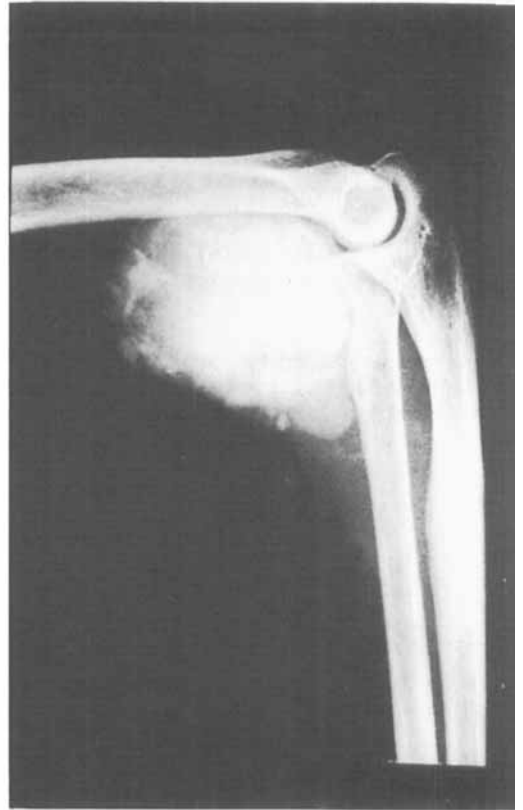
X-ray of the left elbow (January 6, 1977).
